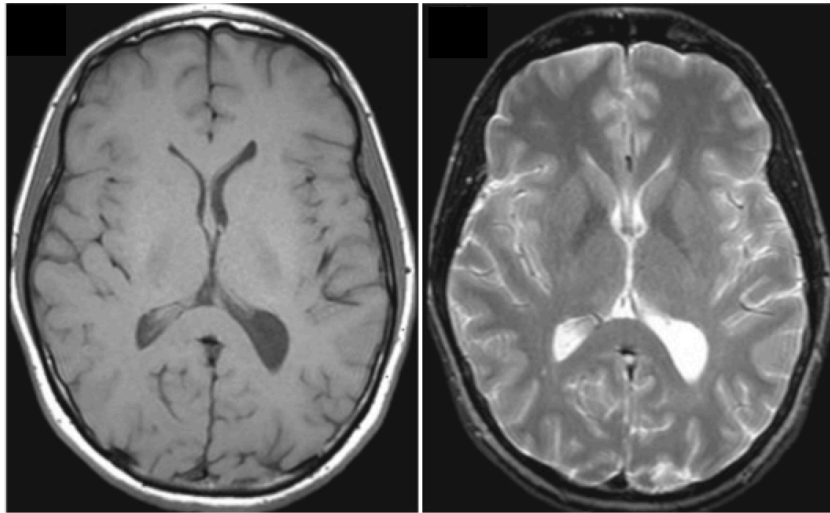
T1- (left) and T2-weighted (right) images of the adult brain.
